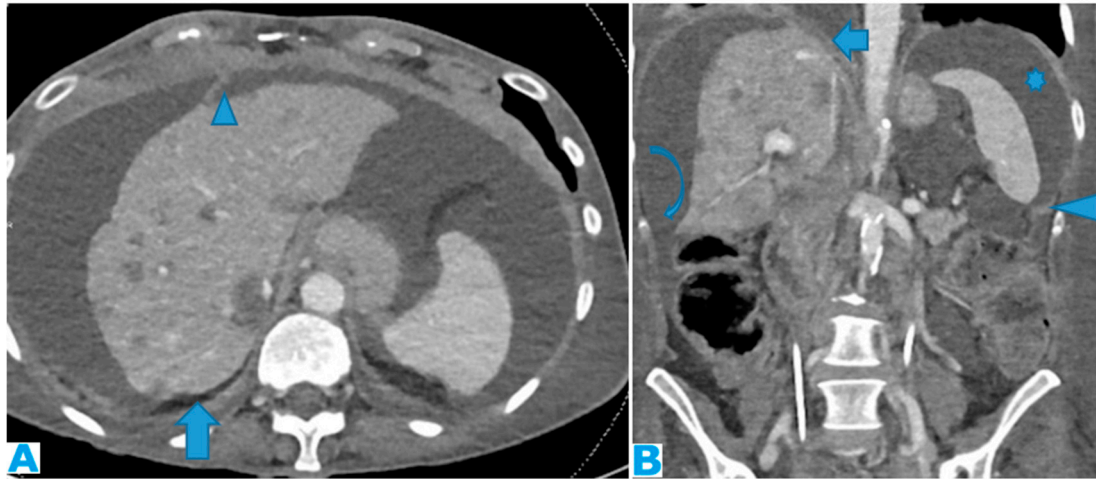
Axial CE-CT (A) and coronal MPR (B). Massive ascites, helpful to differentiate the peritoneal spaces. Observe on A how the posterior margin of the diaphragm (arrow) is not covered by the parietal peritoneum as it is directly in contact with the retroperitoneal fat. The attachment sites of ligaments on the diaphragmatic surface are not covered by peritoneum; Identify on A the falciform and on B, the phrenicocolic ligaments (arrowhead). Notice on B how the phrenicocolic ligament partially separates the left parietocolic gutter from the left subphrenic space (*), whereas the right parietocolic gutter fully communicates with the right subphrenic space (curved arrow). Identify the bare area of the liver on B (arrow), an area directly attached to the diaphragm by connective tissue, thus not covered by peritoneum as neither is its diaphragmatic attachment site.
